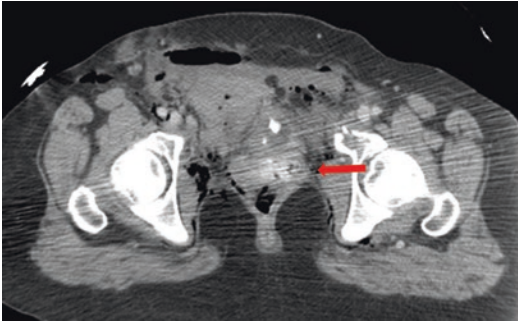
Delayed axial CT cystographic image. Hematoma causes obscuration of the urogenital diaphragmatic fat plane (*short arrow*) and loss of prostatic contour. These findings are suggestive for urethral laceration
